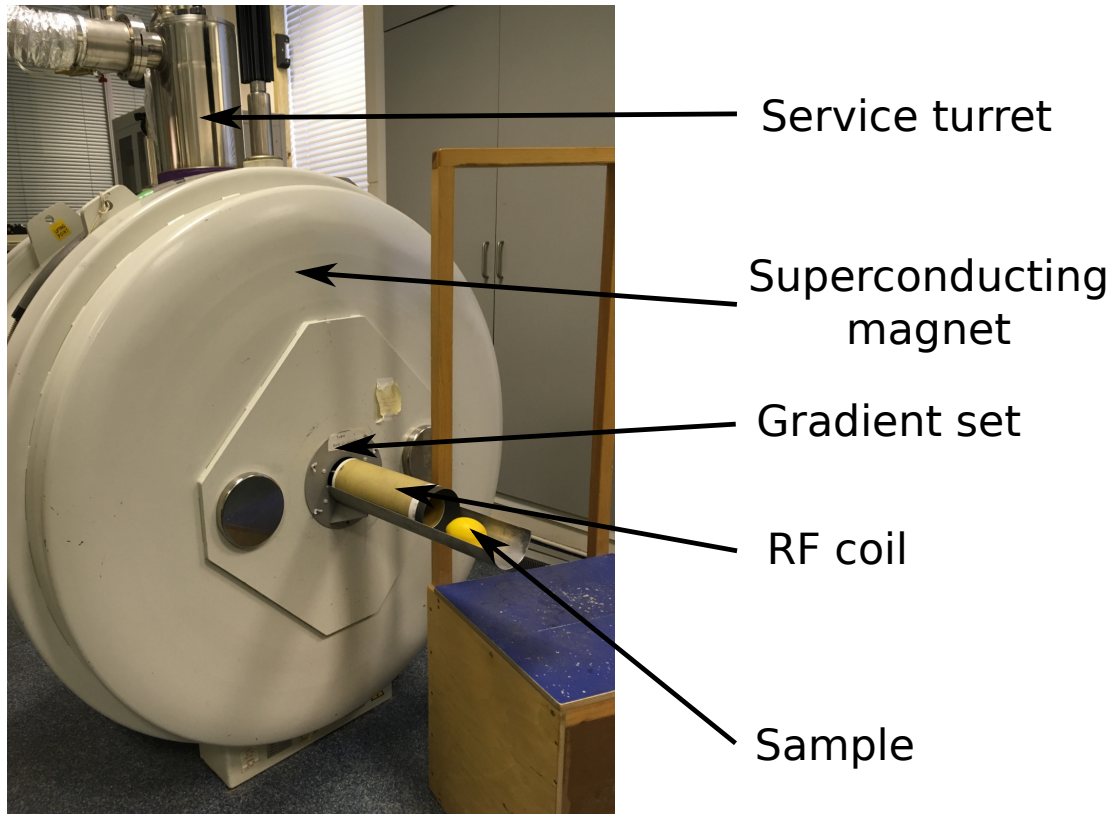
Varian 7T DDR pre-clinical MRI scanner
